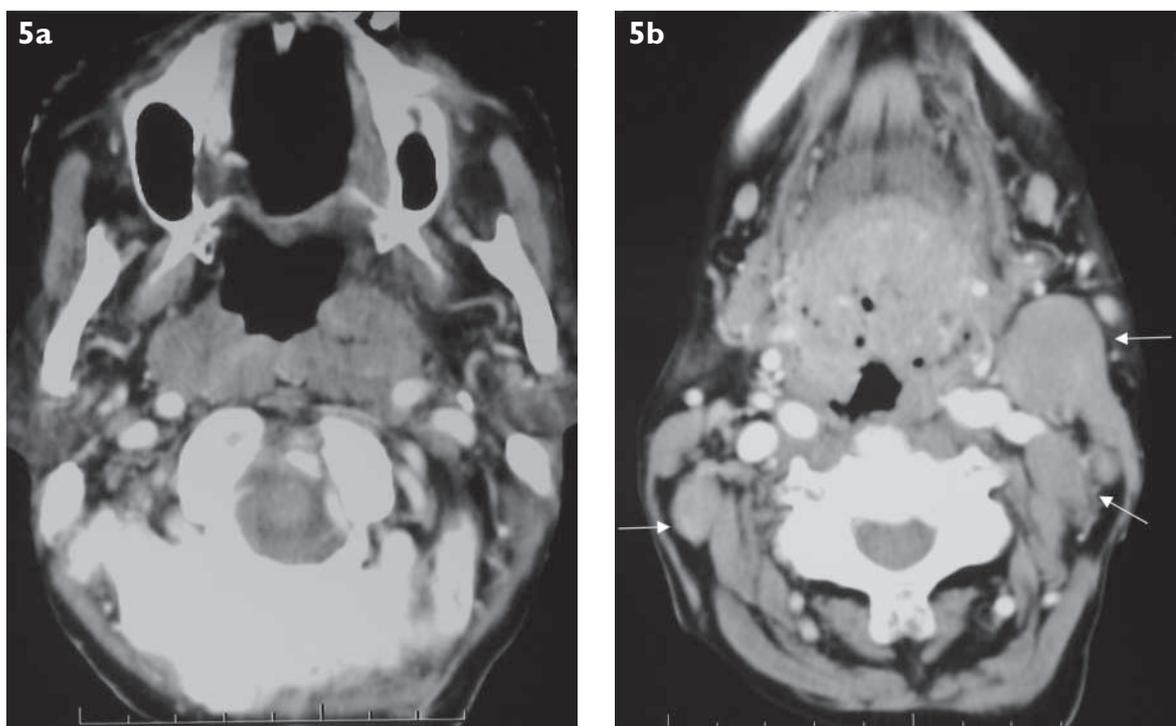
CT appearances of malignant lymphoma in a 64-year-old woman. Enhanced axial CT scan shows (a) fullness in the left nasopharynx with obliteration of the fossa of Rosenmüller and (b) enlarged cervical lymph nodes (arrows).
